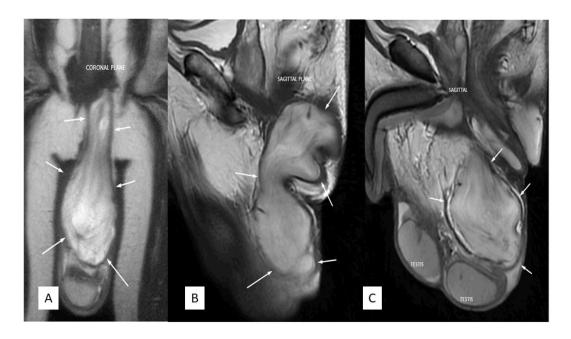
Magnetic resonance imaging (MRI) of perineum
